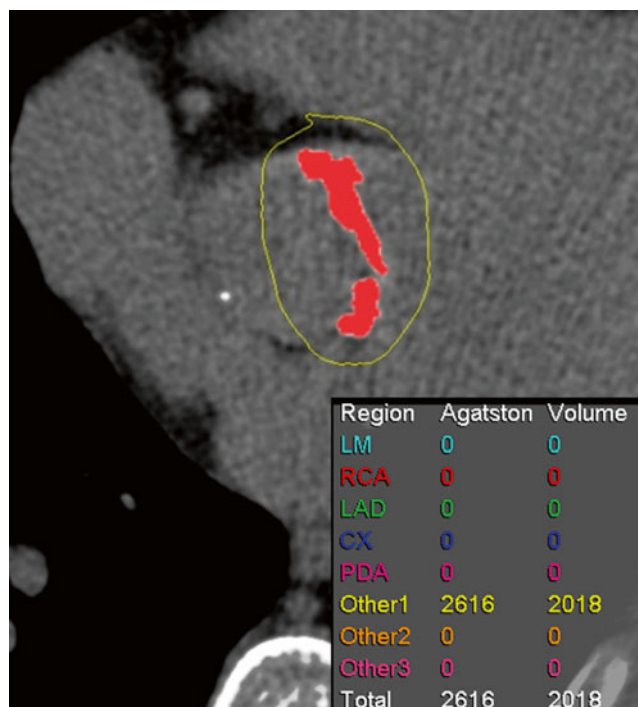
Measurement of valvular calcification. Oblique axial image of pre-contrast CT shows that the amount of aortic valve calcification is expressed as an Agatston score and volume score
